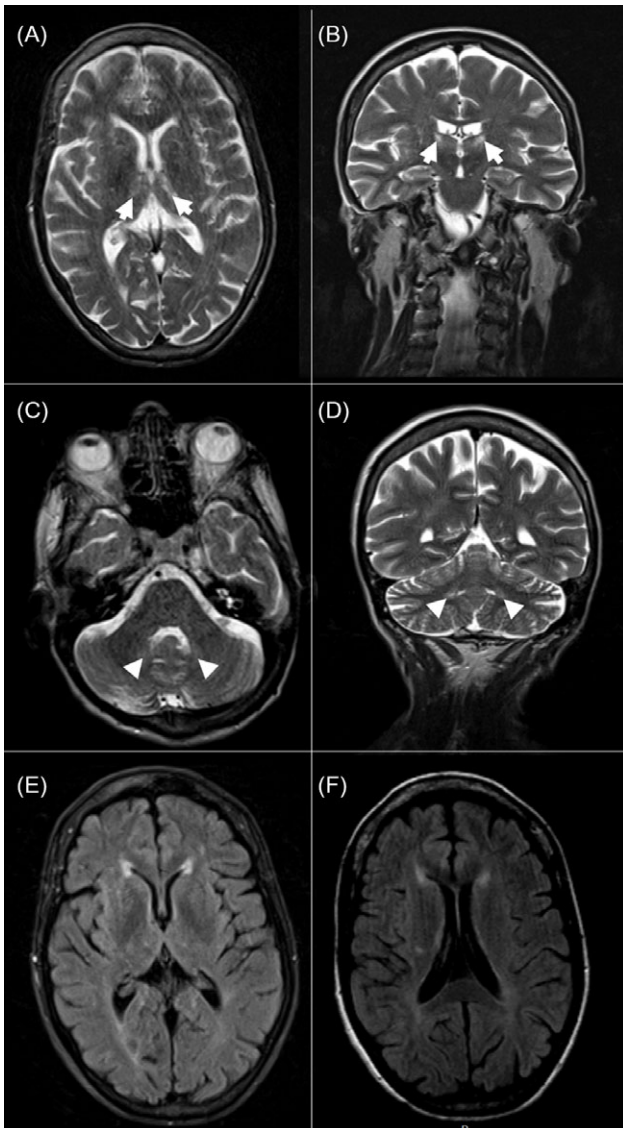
T2-weighted images performed at 49 years of age, showing symmetrical hyperintensity of superior aspects of both thalami (A, B – arrows) and dentate nuclei of cerebellum (C, D – arrowheads). Periventricular white matter hyperintensity on T2-FLAIR sequence was mild (E, F).
